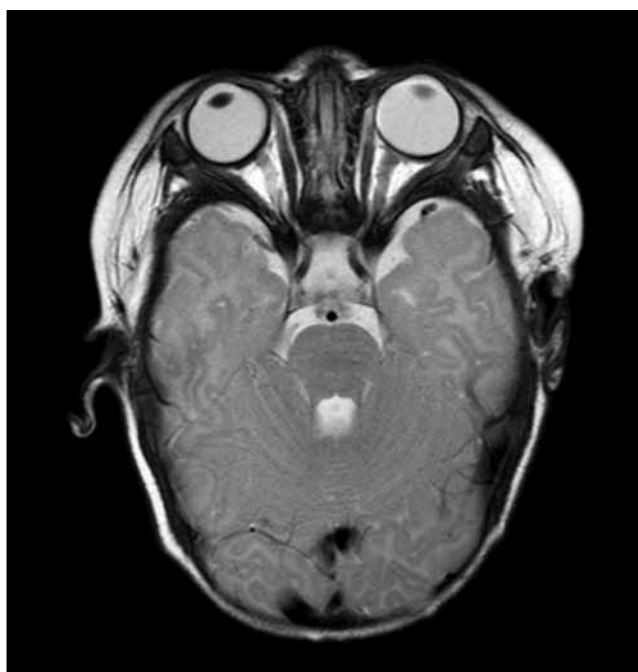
Magnetic resonance imaging of the brain showing normal horizontal rectus muscles in both eyes and no intraorbital mass.
